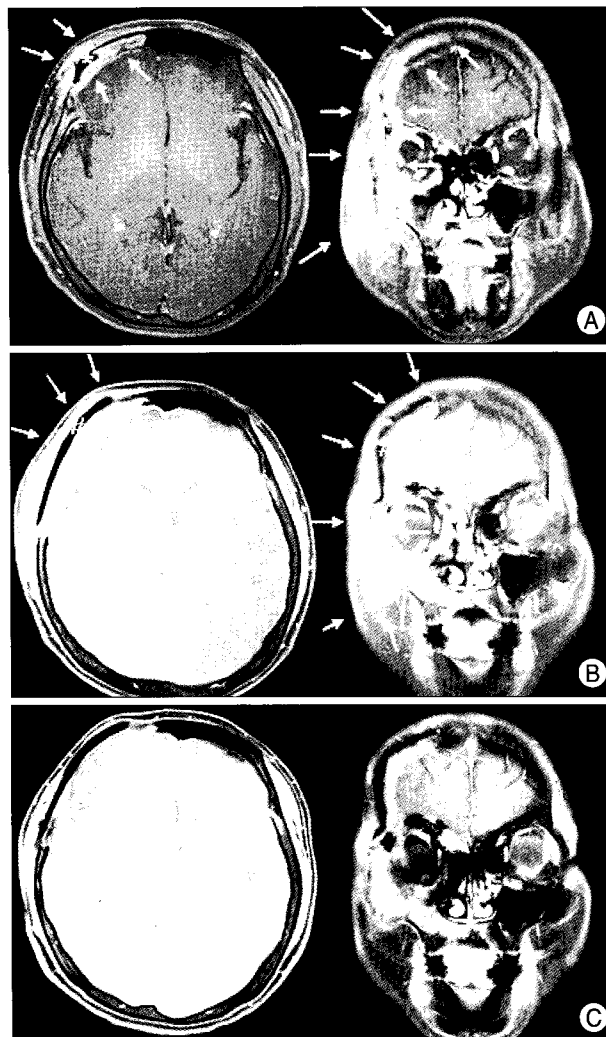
Magnetic resonance images (MRI) of the lesion on admission (arrows). Postgadolinium T1-weighted axial magnetic resonance image shows pericranial abscess appearing as ring-enhancing lesion in the right frontotemporal region and extensive soft tissue infiltrating lesion with destruction of the skull vault (*). The coronal section shows the overall lesions before treatment (A). MRI before change of antifungal agent from amphotericin B to posaconazole shows markedly improved pericranial abscess and periorbital soft tissue lesion in the right frontotemporal region after surgical intervention (B; metallic artifact (#)). Magnetic resonance images of the lesion after treatment completion (C).
